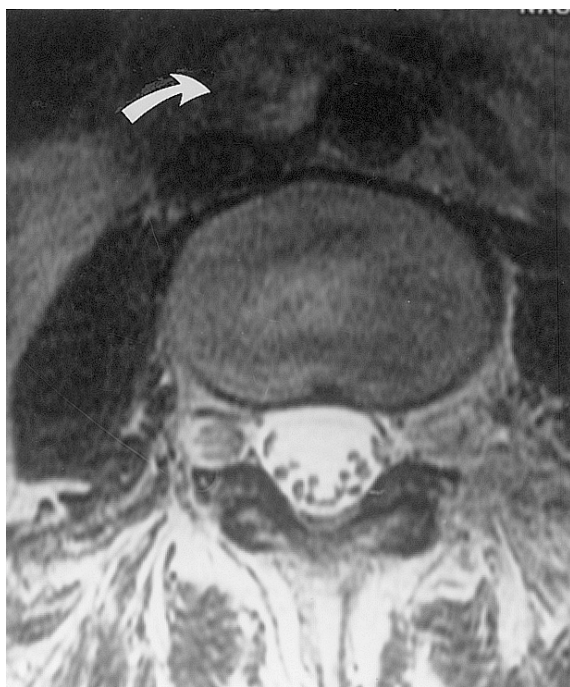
Same patient as in Figs. 3 & 4. Axial T2-W MR image shows a well-circumscribed heterogeneous inter-aortocaval nodule at the level of the inferior mesenteric artery origin, corresponding to the organ of Zuckerkandl (curved arrow).
